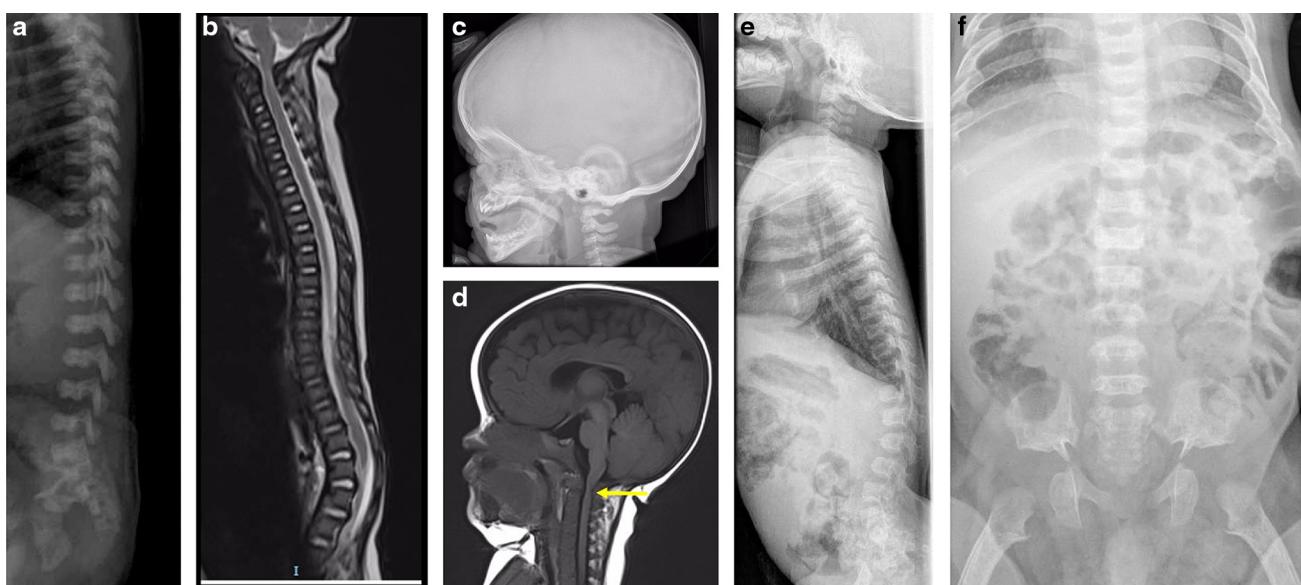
Achondroplasia. Features of achondroplasia at birth (a), at the age of 2 months (b and c) showing the lordosis, at the age of 4 months (d) showing the basilar impression (arrow), and at the age of 1 year (e and f). Radiographs show narrowed vertebrae, kyphosis, typical trident image of the iliac bone and femoral heads looking like an ice-cream cone.
